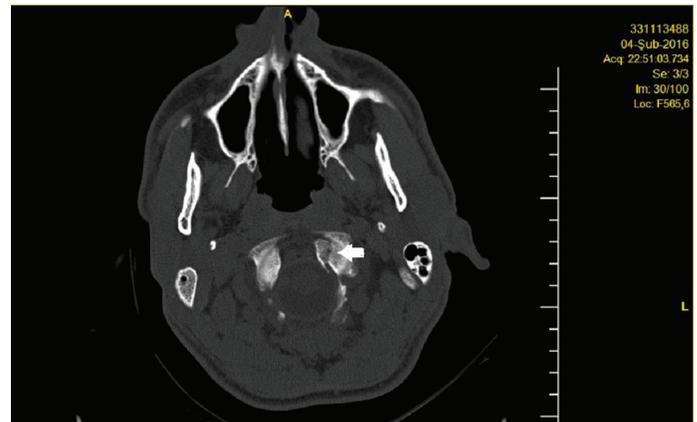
Non -deplase left occipital condyle fracture is observed on axial section of cranial CT
